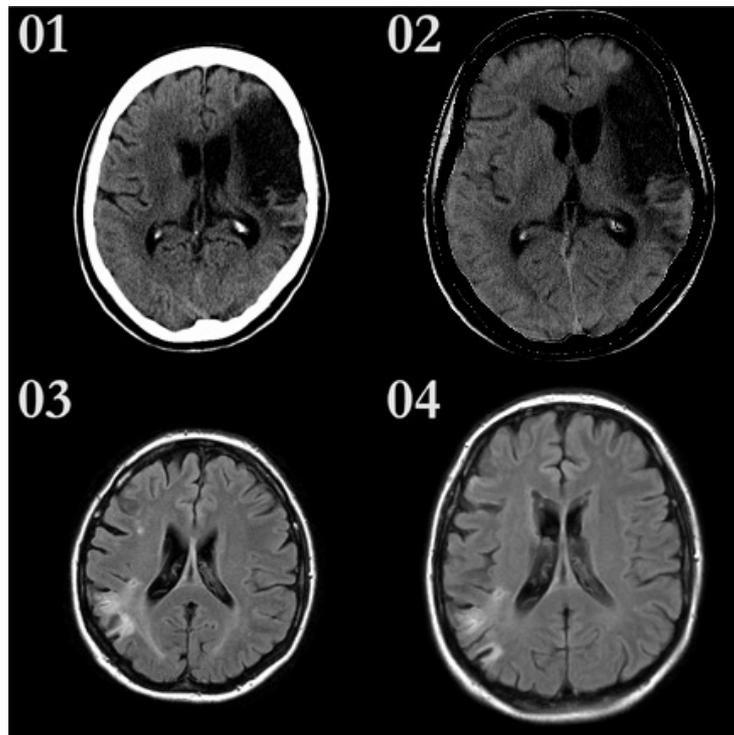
An example of a CT scan before (1) and after (2) transforming it to standard brain template and an example of an MRI scan before (3) and after (4) transforming it to standard brain template.
